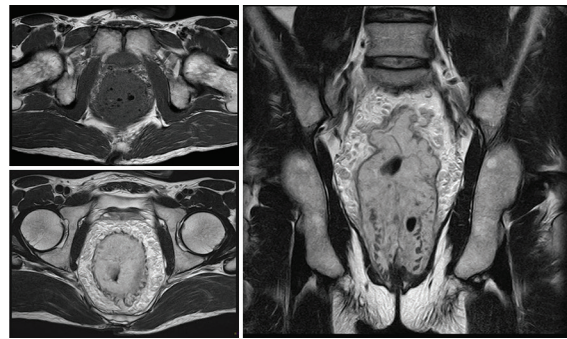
MRI image showing phlebolites and engorged vessels in the perirectal fat.
